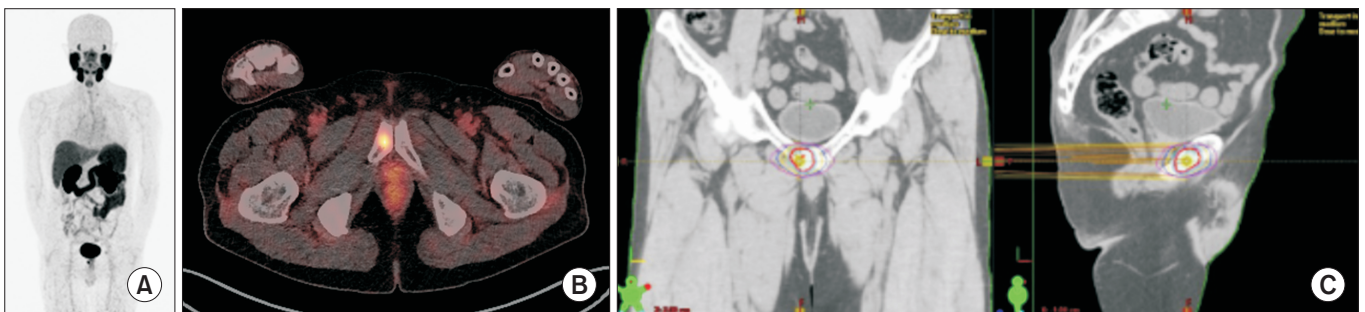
A 69-year-old patient with metastatic castration-resistant prostate cancer involving the left pelvis. Initial management included leuporelin therapy, followed by a combination of triptorelin and bicalutamide. Despite these treatments, the patient exhibited a gradual increase in serum prostate-specific antigen (PSA) levels from 0.074 ng/mL to 0.212 ng/mL within 8 months. (A, B) Prostate-specific membrane antigen (PSMA) positron emission tomography identified a focal PSMA-avid lesion in the right pubic bone. (C) Subsequently, the patient underwent stereotactic ablative radiotherapy to the right pubis with a single fraction of 22 Gy, leading to a reduction in PSA levels from 0.212 ng/mL to 0.053 ng/mL.
